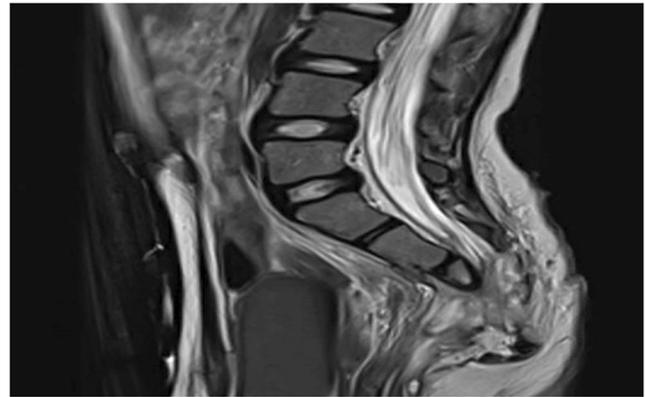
Postoperative sagittal T2-weighted MRI shows obliteration of the anterior sacral meningocele after neurosurgical exploration and evacuation of the empyema
